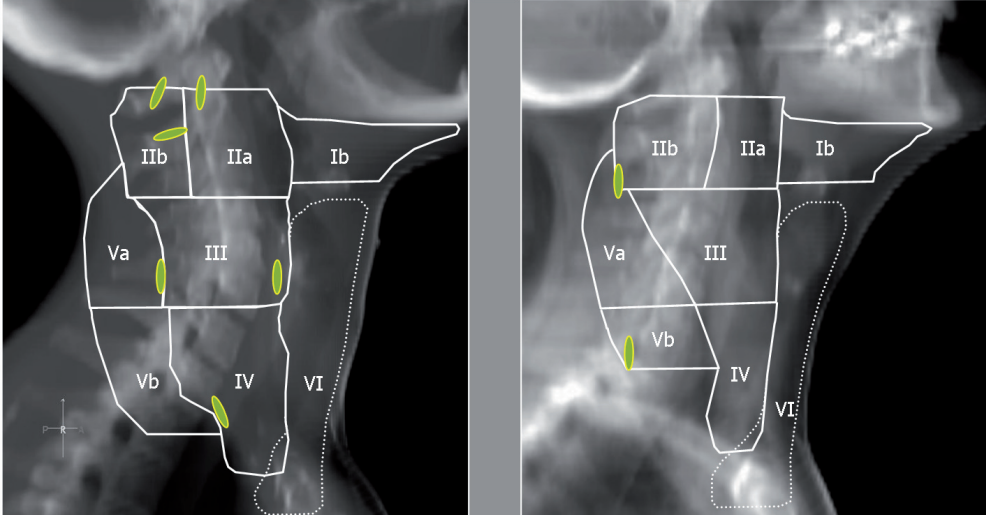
Digitally reconstructed radiographs validated the position of clips at cranial border IIa, IIb and boundaries level III, Va, and IV, Vb. (left panel). Digitally reconstructed radiographs validated the position of intra-operatively defined clips, demarcating boundaries of levels IIb, Va and Vb, as they were in good agreement with previously contoured (and matched) CT-base boundaries (right panel). *I.J.R.O.Biol. Phys* 2005;62:3:690-699.
